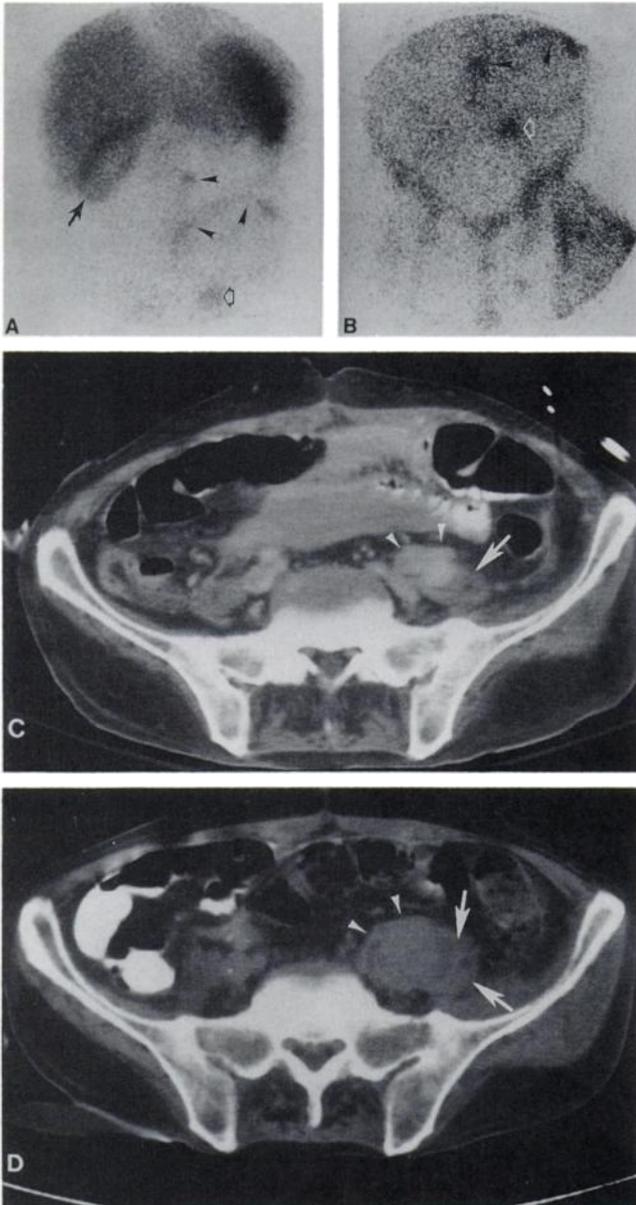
A 48-yr-old man (Patient 4) with subacute bacterial endocarditis, positive blood cultures and recent embolic events. (A and B) WBC scan shows focal uptake in gallbladder fossa (arrow) and bowel activity (arrowheads), focal uptake in the left midpelvis (open arrow), and diffuse uptake in the left upper thigh. Initial CT and a second CT scan 1 wk later did not show focal pelvic abnormality due to ileus and ascites. (C) Third CT scan 1 wk later showed a soft-tissue mass (arrow) adjacent to a left common iliac artery aneurysm (arrowheads). (D) Fourth CT scan 4 wk after the WBC scan showed a mixed-density mass in the left psoas region (arrow), involving the left common iliac aneurysm (arrowheads). An infected pseudoaneurysm of the left common iliac artery was found at surgery. The patient had also undergone prior operations for empyema of the gallbladder and debridement of an infected left thigh after a recent above the knee amputation.
